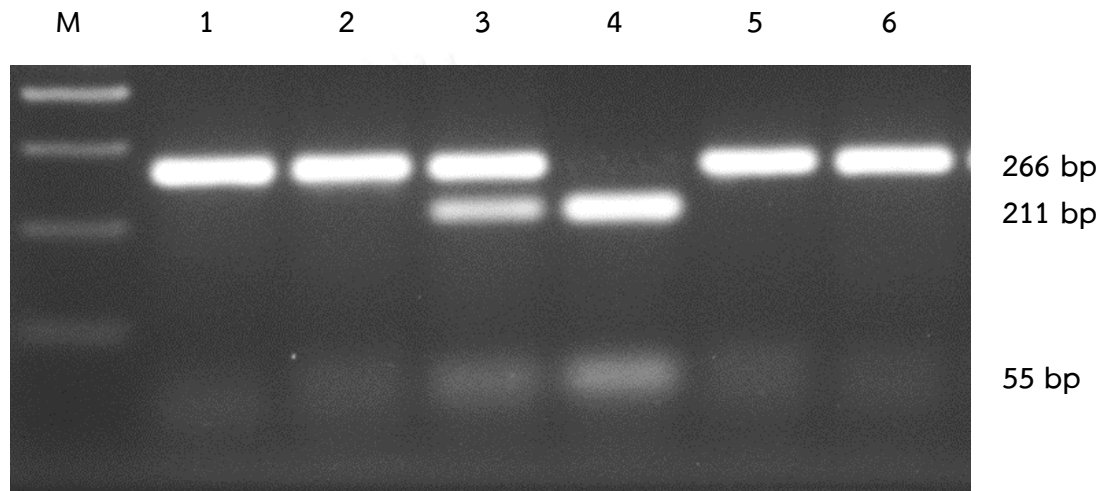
Example of genotypic pattern of the *VEGF* +936C/T polymorphism. Lane M: DNA ladder (100 bp + 1.5 Kb (SibEnzyme ltd., Russia)), Lane 1-2 and 5-6: 266 bp fragment represent CC genotype, Lane 3: 55, 211 and 266 bp fragment represent CT genotype, Lane 4: 55 and 211 bp fragments represent TT genotype.
